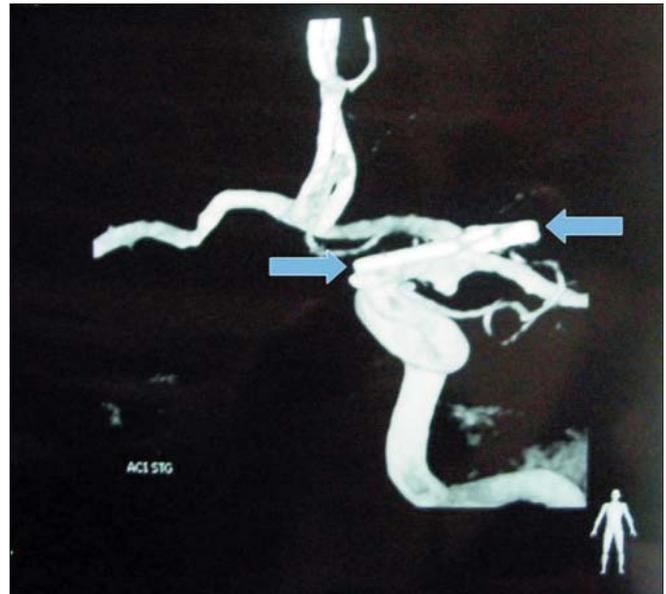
The patient's angio CT showing the position of the clip. Note the complete obliteration of the aneurysm
